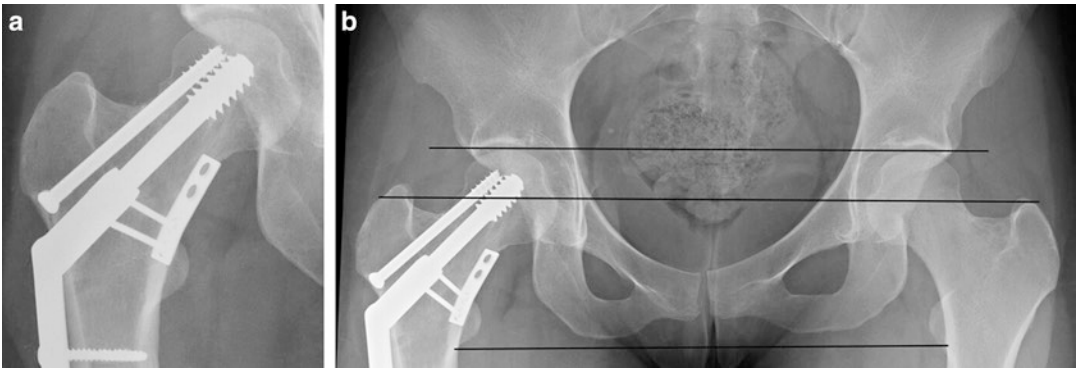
(a, b) Final radiographs show healed fracture and minimal femoral neck shortening
